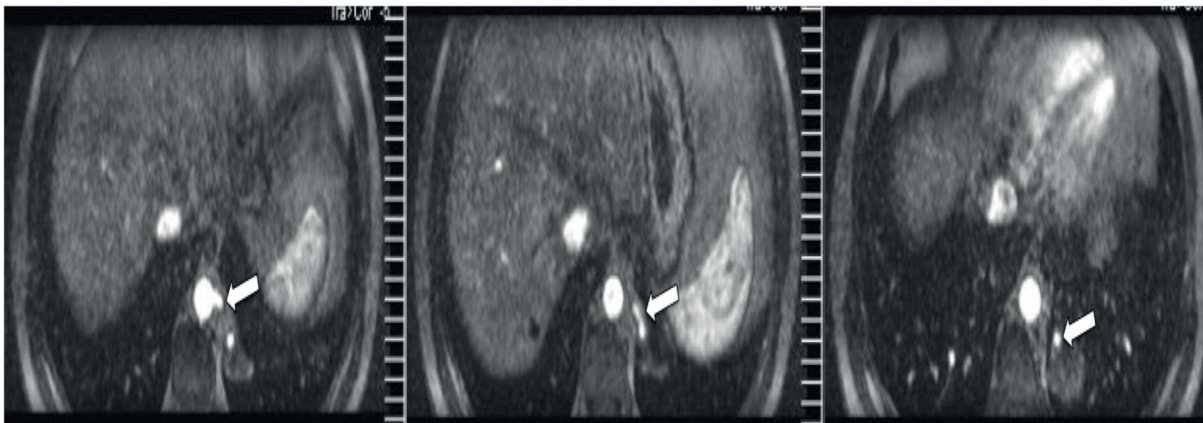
Contrast-enhanced thoracic MRI showing an arterial vessel that arose directly from the lateral aspect of the aorta supplied the left lower lobe mass, consistent with a pulmonary sequestration (Arrows).
